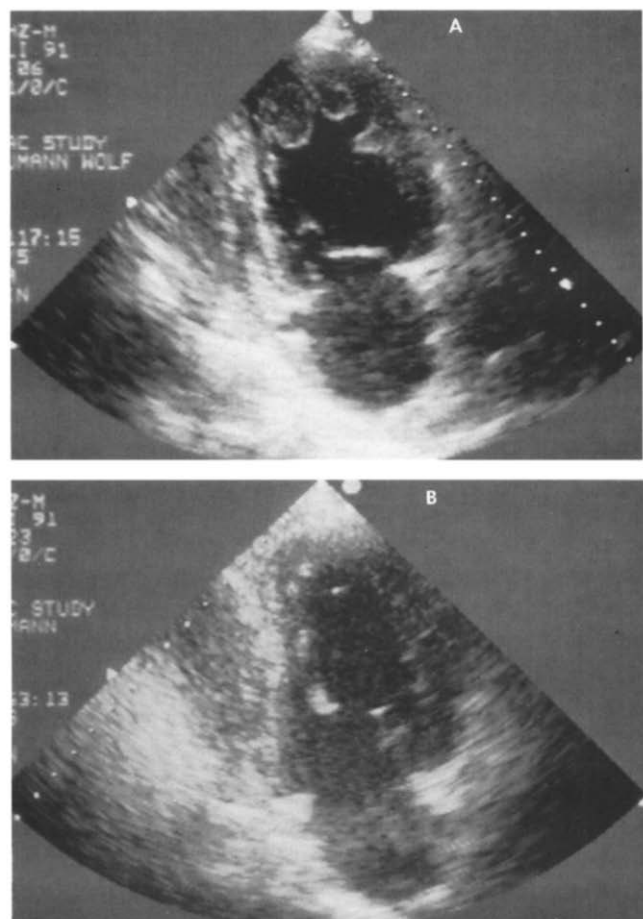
A. Apical long-axis view echocardiogram showing three protruding and mobile thrombi in a drug addict with mild global hypokinesia of a mildly dilated left ventricle. B. Two weeks after high dose intravenous heparin administration, all left ventricular thrombi disappeared, both in the same imaging plane and in all other views (not shown).
